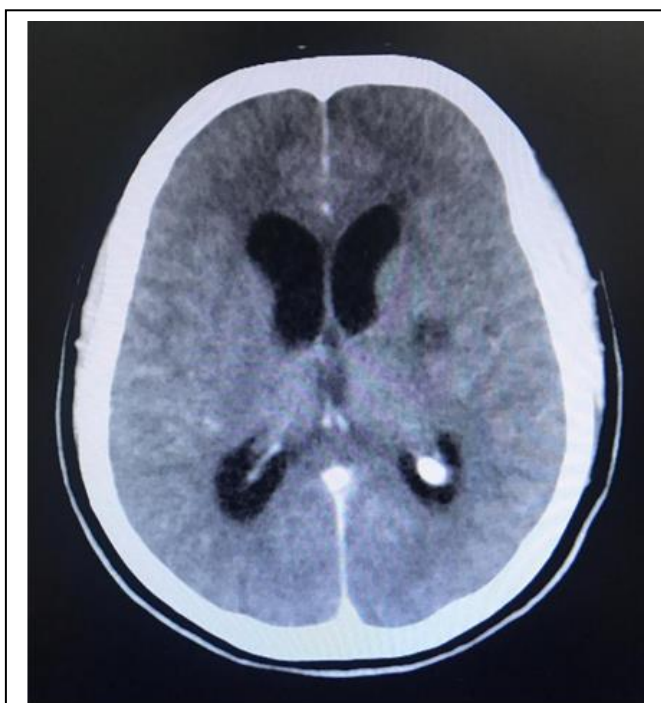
CT scan of the brain showing a hypodense mass lesion on the left hemisphere and ventricular enlargement.
